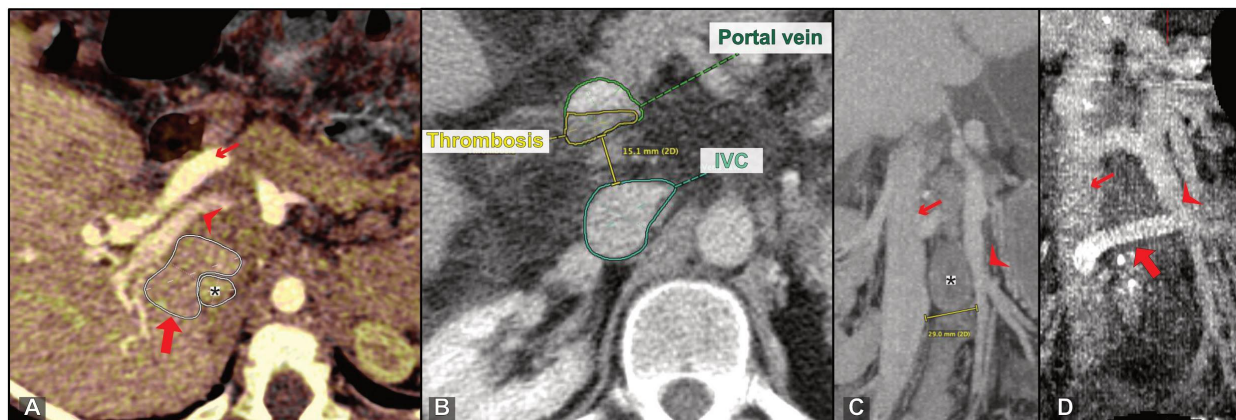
Factors of complexity; A: Oblique axial CT (fused portalvenous phase and venous phase) shows an interposing caudate lobe (PSS procedure: portacaval end-to-side with subsegmental liver resection); bold arrow: caudate, arrowhead: portal vein, small arrow: hepatic artery, asterisk: IVC. B: Axial CT with a partial thrombosis of the extrahepatic portal vein (PSS procedure: portacaval side-to-side after thrombectomy); C: Oblique coronal CT MIP shows a large distance between IVC (small arrow) and SMV (arrowhead) of 29 mm. This patient received a graft interposition (allograft), which is seen in D (PSS procedure: mesocaval with the use of a graft interposition); D: Postoperative, oblique coronal CT MIP reconstruction shows the graft interposition (bold arrow) that connects SMV (arrowhead) and IVC (small arrow). (Reprinted with permission from Fehrenbach U, Gül-Klein S, de Sousa Mendes M, et al. Portosystemic shunt surgery in the era of TIPS: imaging-based planning of the surgical approach. *Abdom. Radiol.* (2020))
